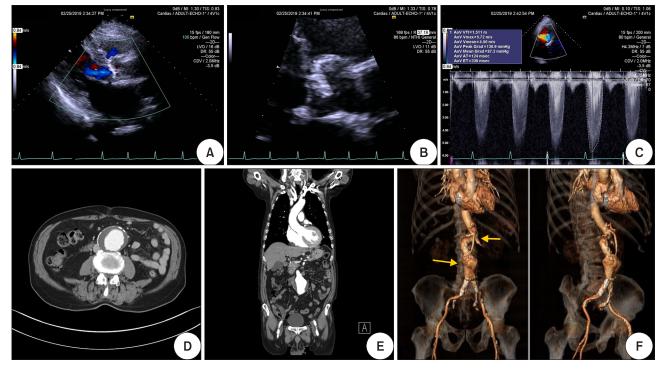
(A, B) Echocardiography showed heavily calcified aortic valve with a peak velocity of 5.72 m/s, and mean pressure gradient of 87.2 mmHg. (D-F) Computed tomography showed aneurysmal dilatation of the infra-renal abdominal aorta (yellowish arrows).
